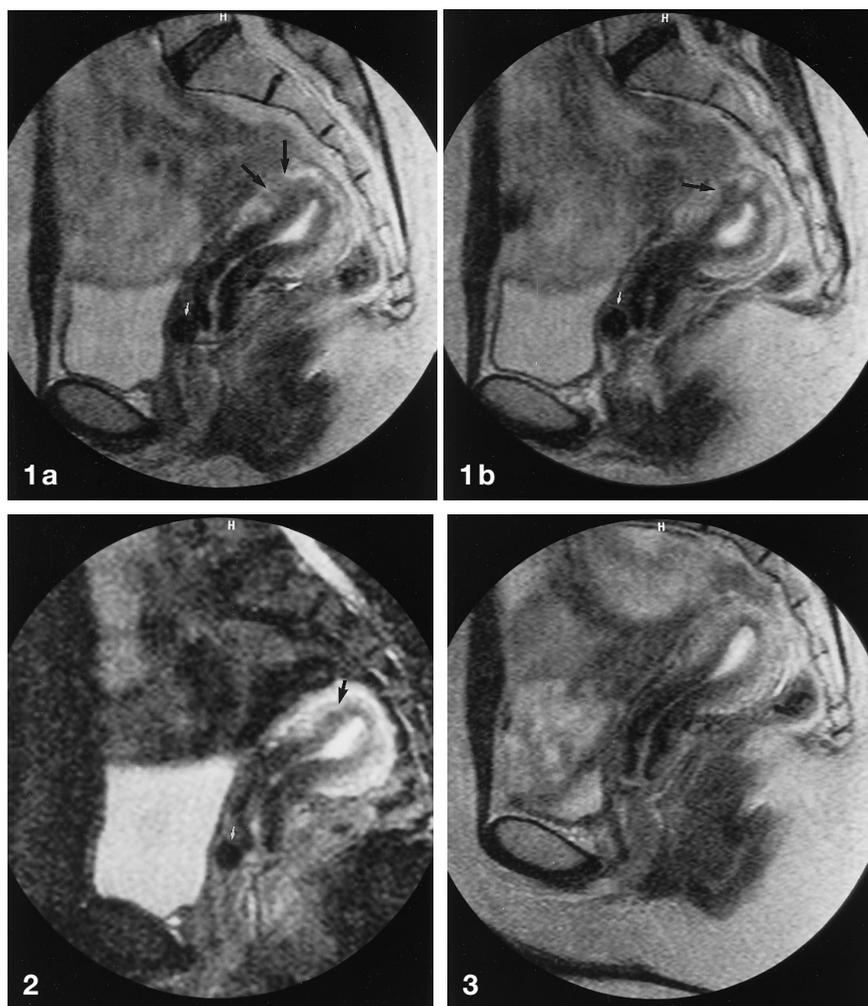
a, b. T2-weighted consecutive sagittal MR images show a focal, ill-defined area of low signal intensity on the anterior wall of the retroverted uterus, inseparable from the junctional zone, which is mimicking the adenomyosis (*black arrows*). Note the discrete bulging of the junctional zone into the endometrial cavity. The round low-intensity aspect in the anterior vaginal fornix is due to a tampon (*white arrow*)
